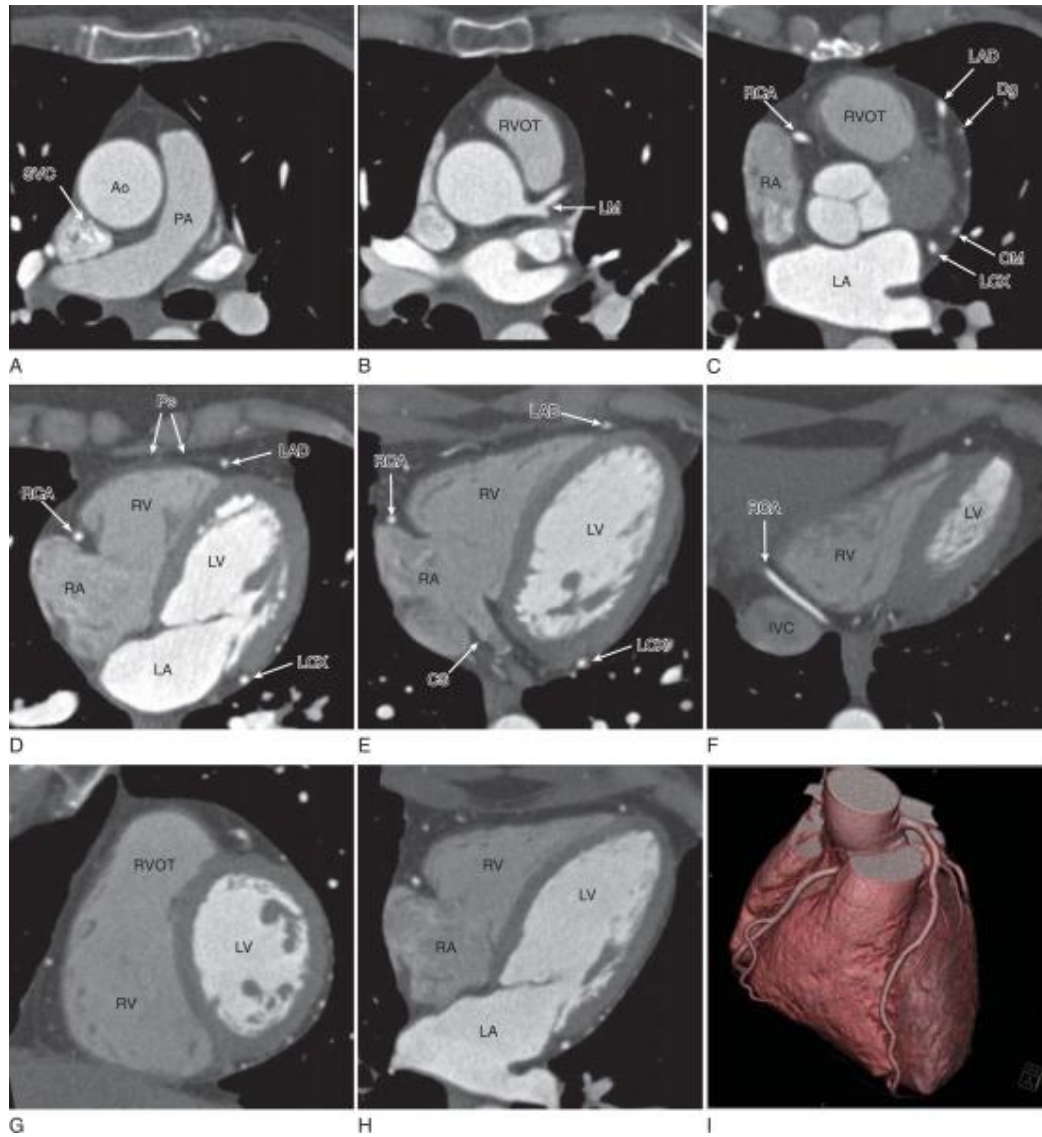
showing normal cardiac anatomy as depicted by contrast-enhanced multidetector computed tomography
